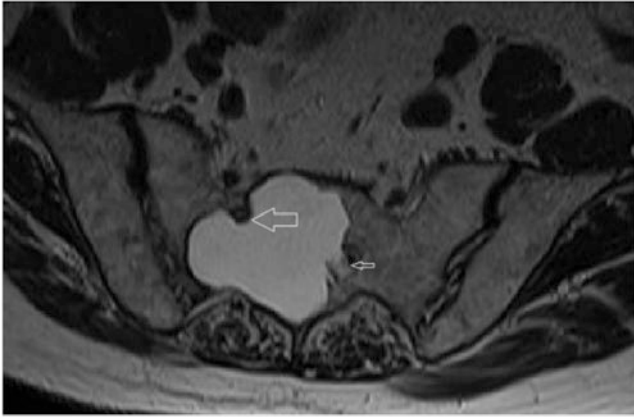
T2-weighted axial section showing Tarlov cyst arising from right S2 nerve root (*large arrow*) causing bony erosion and contralateral nerve root compression (*small arrow*)
